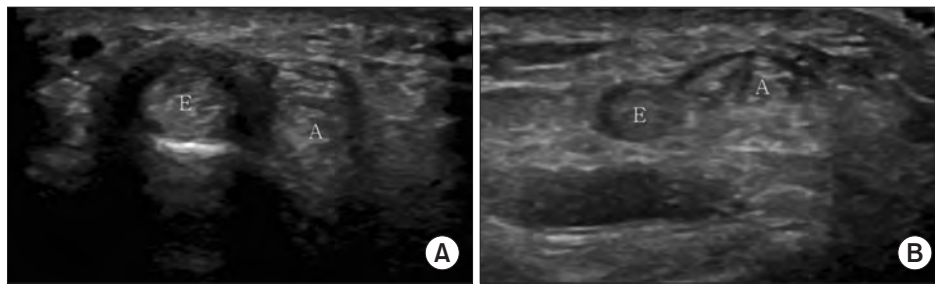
Ultrasonographic images of the first extensor compartment of the wrist, specifically focusing on the number of abductor pollicis longus (APL) tendons present. E: extensor pollicis brevis, A: abductor pollicis longus. (A) The “single APL” section of the image shows a single APL tendon in the first extensor compartment. This represents a less-common anatomical variation. (B) The “multi APL” section shows multiple APL tendons within the first extensor compartment. This is the most common anatomical pattern, present in 57% of wrists, typically consisting of 2 APLs and 1 extensor pollicis brevis in the compartment. However, the exact number of APL tendon slips can vary and may be difficult to identify using ultrasound due to incomplete division, crowding, or anisotropic effects.
